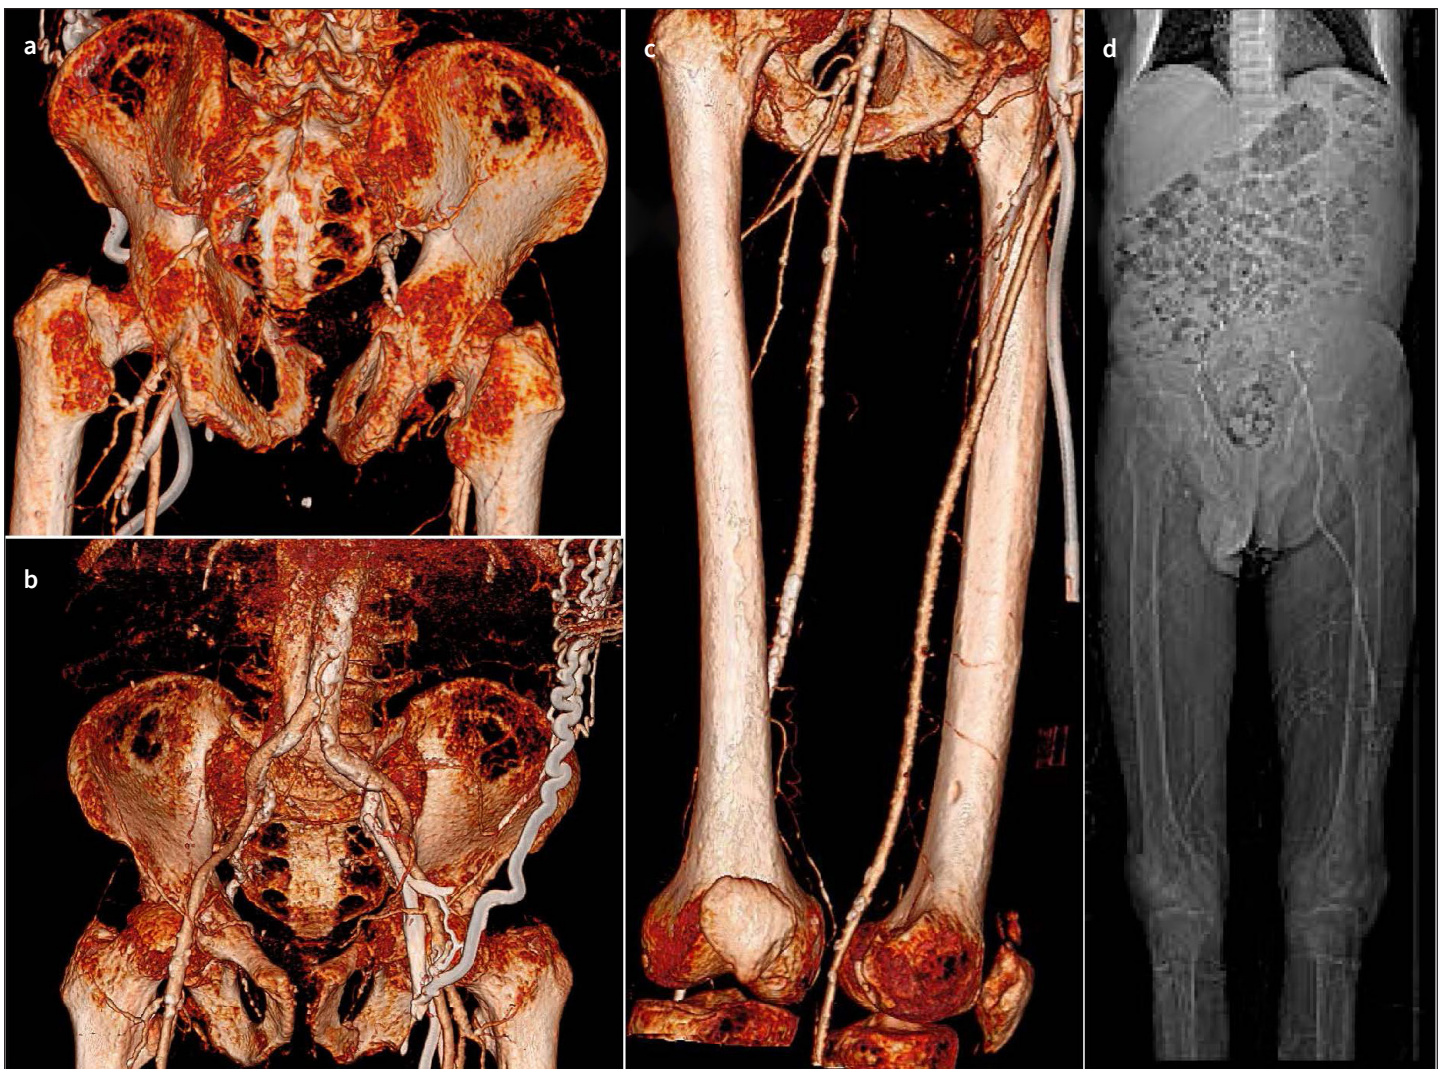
a-d. a) and b) Posterior and anterior views of the 3D reconstruction of computed tomography of the pelvic region shows severe bone resorption throughout the pelvic bones, vertebral processes, and femoral trochanters and necks; widening of the sacral foramina; perforation of the alae iliums; and excessive calcification of the abdominal aorta and its branches. c) 3D reconstruction of the leg area reveals severe bone resorption at the femoral and tibial condyles with an appearance similar to perforations and excessive calcification of the femoral arteries and their branches. d) An X-ray of the body shows diffuse low bone density and left femoral hemodialysis catheter.
